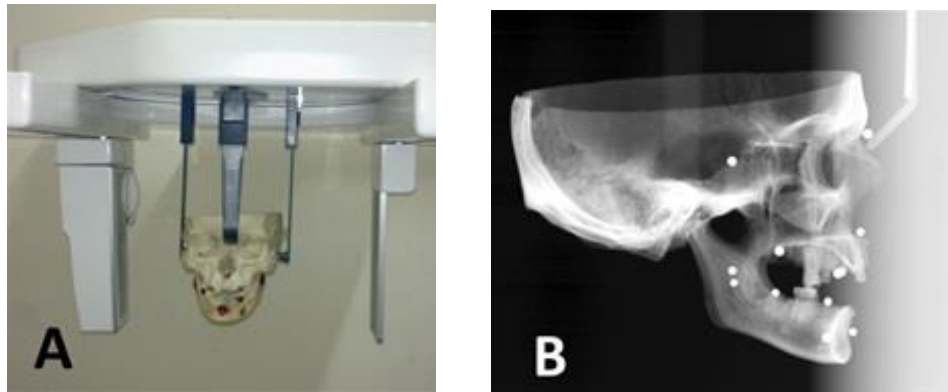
A- Positioning of skull containing metallic markers on the cephalostat. B- Cephalometric radiograph of skull showing the radiopaque markers.
